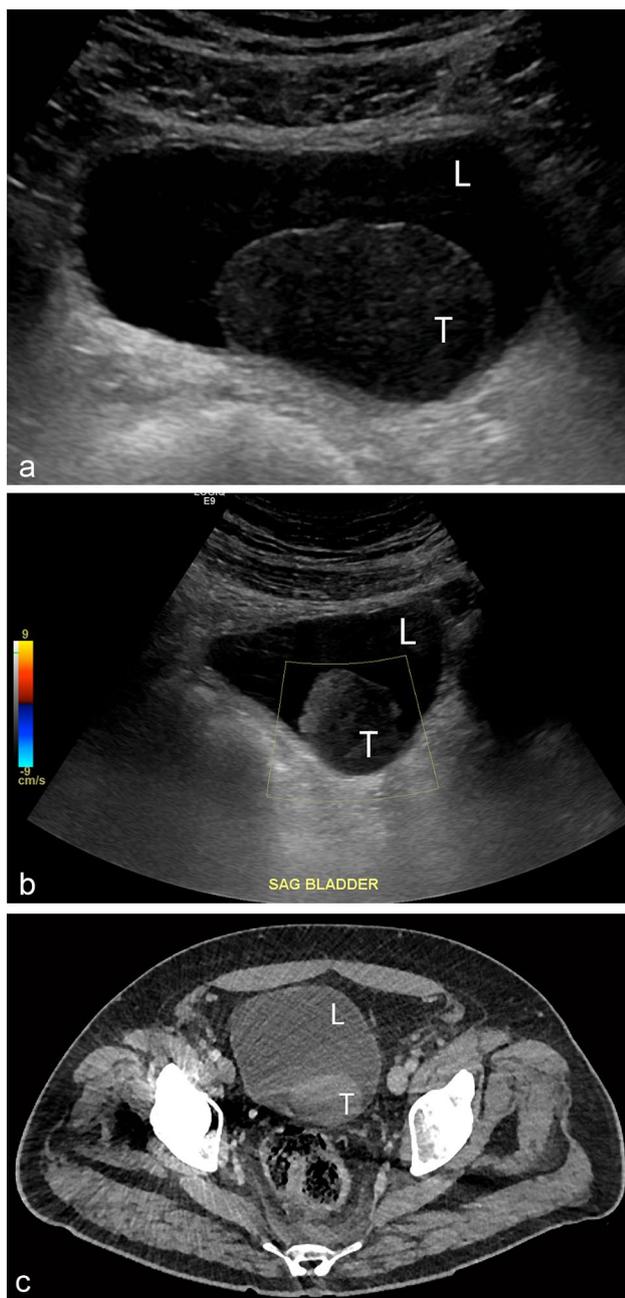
63-year-old male with large bladder thrombus. a Transverse grayscale ultrasound view of the bladder shows a large, hypoechoic, well-circumscribed mass within the bladder. b Transverse ultrasound view of the bladder with color Doppler overlay shows no vascularity within the mass. c Axial contrast-enhanced CT confirms a large rounded mildly hyperdense intraluminal mass confirmed to represent large thrombus on cystoscopy. The patient had a history of clear cell renal cell carcinoma status post partial nephrectomy complicated by a pseudoaneurysm, which caused hematuria and led to the bladder thrombus. *L* bladder lumen; *T* thrombus
